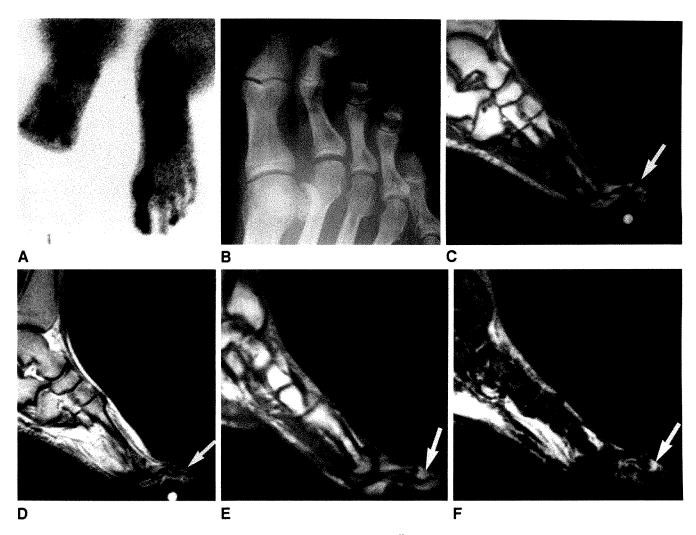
Cellulitis of third toe and neurotrophic changes of big toe in 55-year-old man. 99mTc-methylene diphosphonate (MDP) bone scintigram (A) shows increased uptake in region of first and third toes. Plain radiograph (B) shows essentially normal third toe and destructive changes of asymptomatic big toe. Findings in big toe are consistent with neurotrophic changes. MR of third toe (C and D, arrow) shows essentially normal bone-marrow signal on both T1-weighted (683/20) (C) and T2-weighted (2016/100) (D) images. High-signal bath-oil bead at ventral aspect of third toe is a marker for ulcer. MR of big toe also shows normal bone marrow on T1-weighted image (683/20) (E, arrow) and closely corresponding short-tau inversion recovery (STIR) image (2116/150) (F). Soft-tissue edema (F, arrow) around big toe near destructive area can be seen on STIR image. Abnormal signal in soft tissue on dorsal and plantar aspects of foot, best shown on T2-weighted (D) and STIR (F) images, occurs frequently in diabetic patients with or without evidence of infection.
